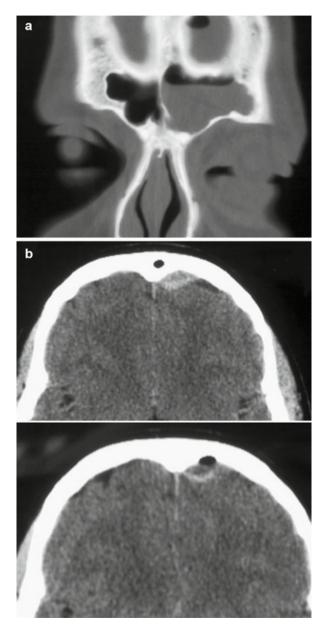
Frontal lobe pneumococcal abscess secondary to frontal sinusitis. (a) Coronal CT showing opacification of left frontal sinus. (b) Axial CT demonstrating abscess of frontal lobe
